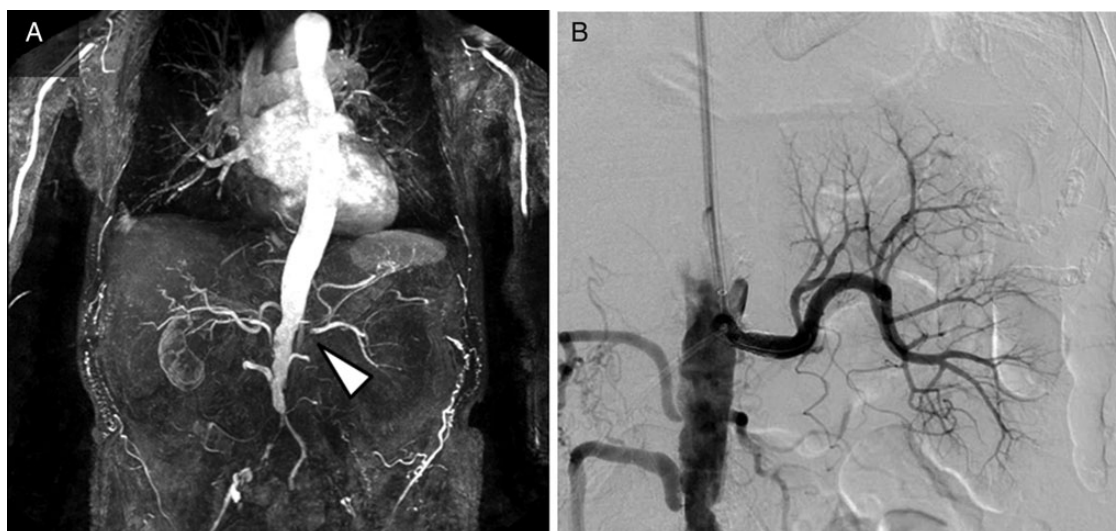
Angiographies of the left renal artery before and after percutaneous luminal angioplasty. (A) Angio-MRI showing the absence of vascularization of the left kidney secondary to an ostial occlusion of the left renal artery (arrowhead). Collateral vascularization suggests chronic blood flow limitation due to atherosclerotic disease. The distal aorta is completely occluded. Haemodialysis was performed immediately after the procedure and on the day after to limit the risk of nephrogenic systemic fibrosis. (B) Arteriography after percutaneous angioplasty of the left renal artery with successful blood flow restoration.
